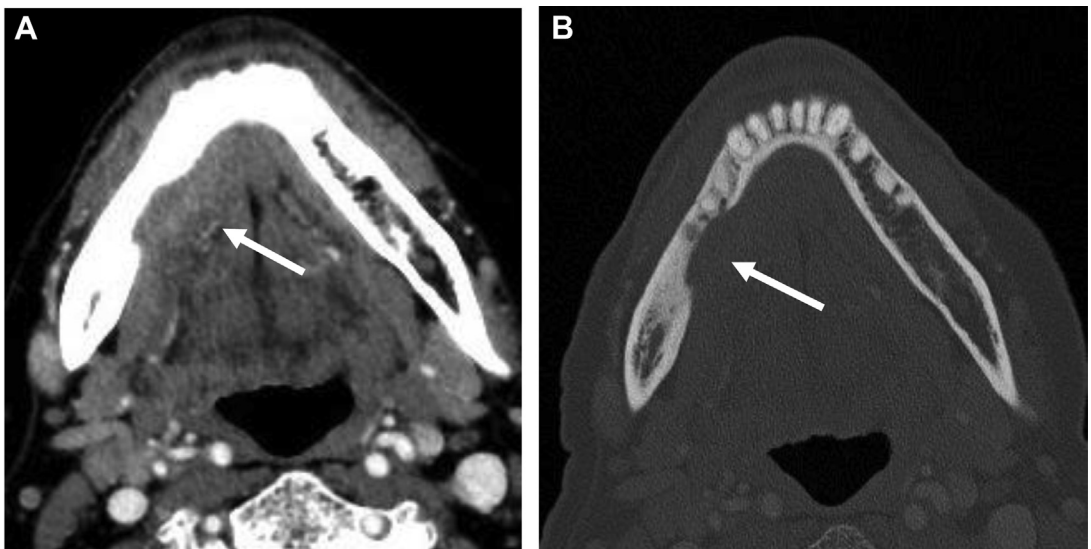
CT findings of bone erosion. (*A*) Axial contrast-enhanced CT shows a right floor of mouth carcinoma (*arrow*). (*B*) Bone algorithm shows erosion of the adjacent lingual cortex (*arrow*).
